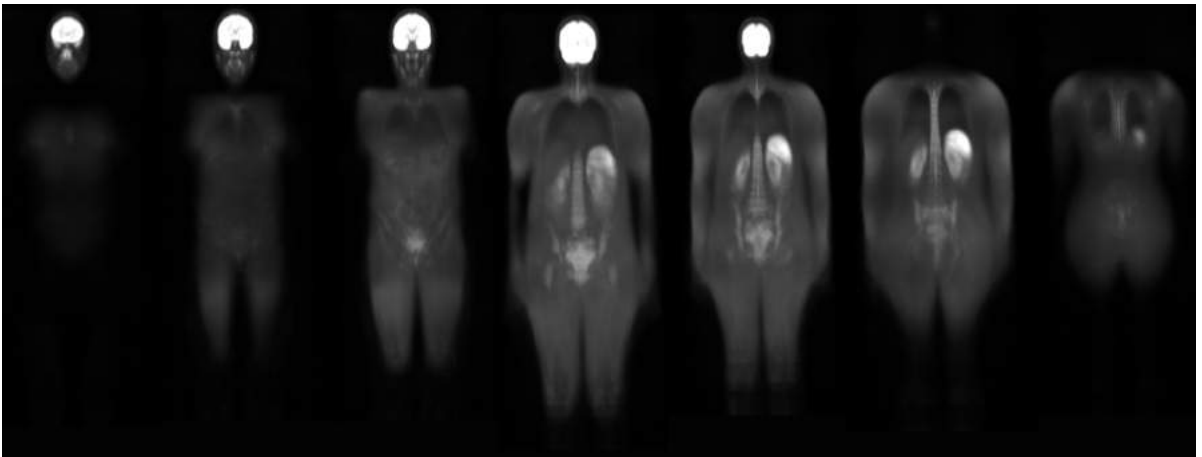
Final female atlas, built with 32 DWI male images. These seven coronal representative slices show that the normal hyperintense organs achieved good alignments, using a mean image as the fixed image.
